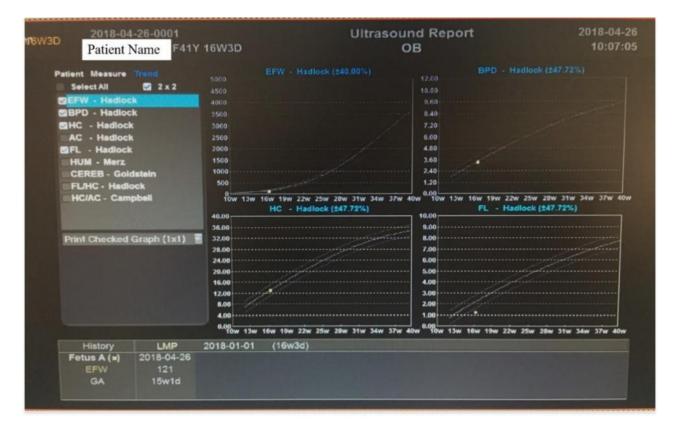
The B-ultrasound report.
